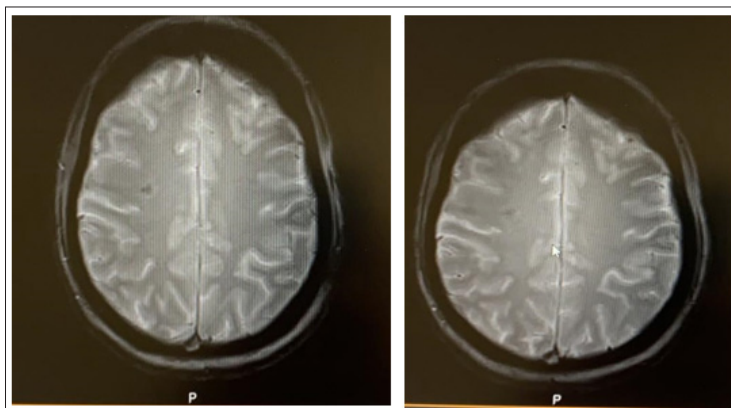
MRI Brain March 2020 (left) and March 2021 (right) (axial view) showing stable disease of the brain metastasis (which is now calcified) with no new metastasis.
